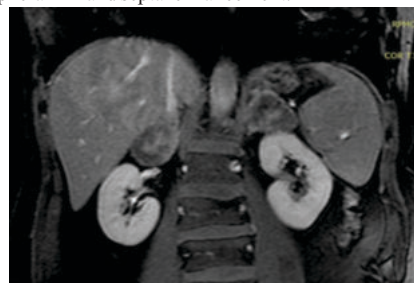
MRI abdomen: B/L enlarged adrenals with peripheral rim and septal enhancement
